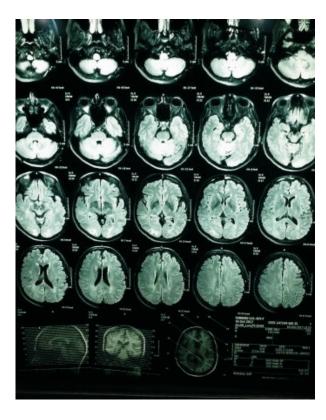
MRI flare image showing high signal intensity in both occipital lobes
